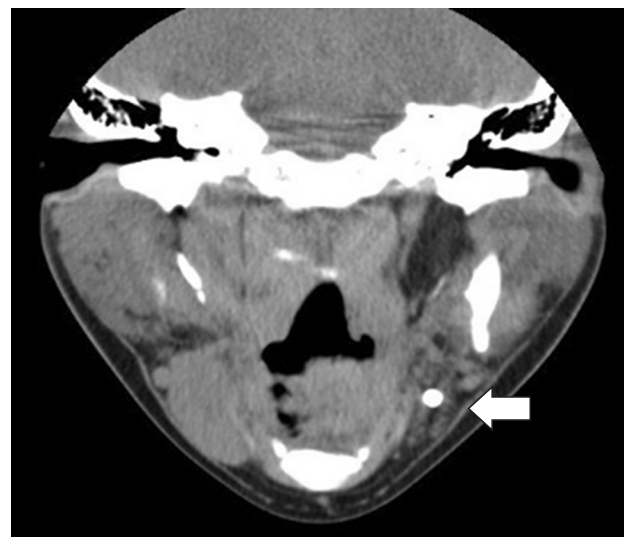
Computed tomographic image showed atrophied submandibular gland on left side (arrow).
